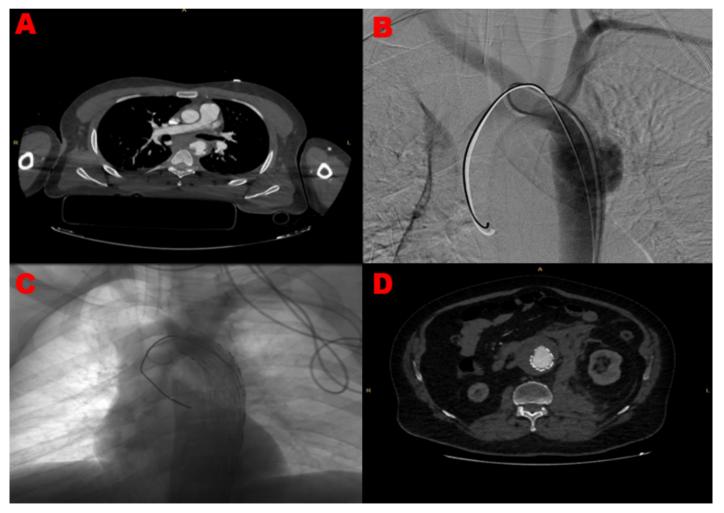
Imaging findings and endovascular interventions in patients with ruptured aortic pathologies; A. Axial CT scan showing a ruptured thoracic aorta due to traumatic aortic transection following a traffic accident; B. Digital Subtraction Angiography (DSA) image displaying the ruptured thoracic aorta with aortic transection; C. Post-TEVAR image of the same patient, demonstrating the endovascular repair of the thoracic aorta; D. Axial CT scan showing a ruptured abdominal aorta with successful endovascular aneurysm repair (EVAR) placement
